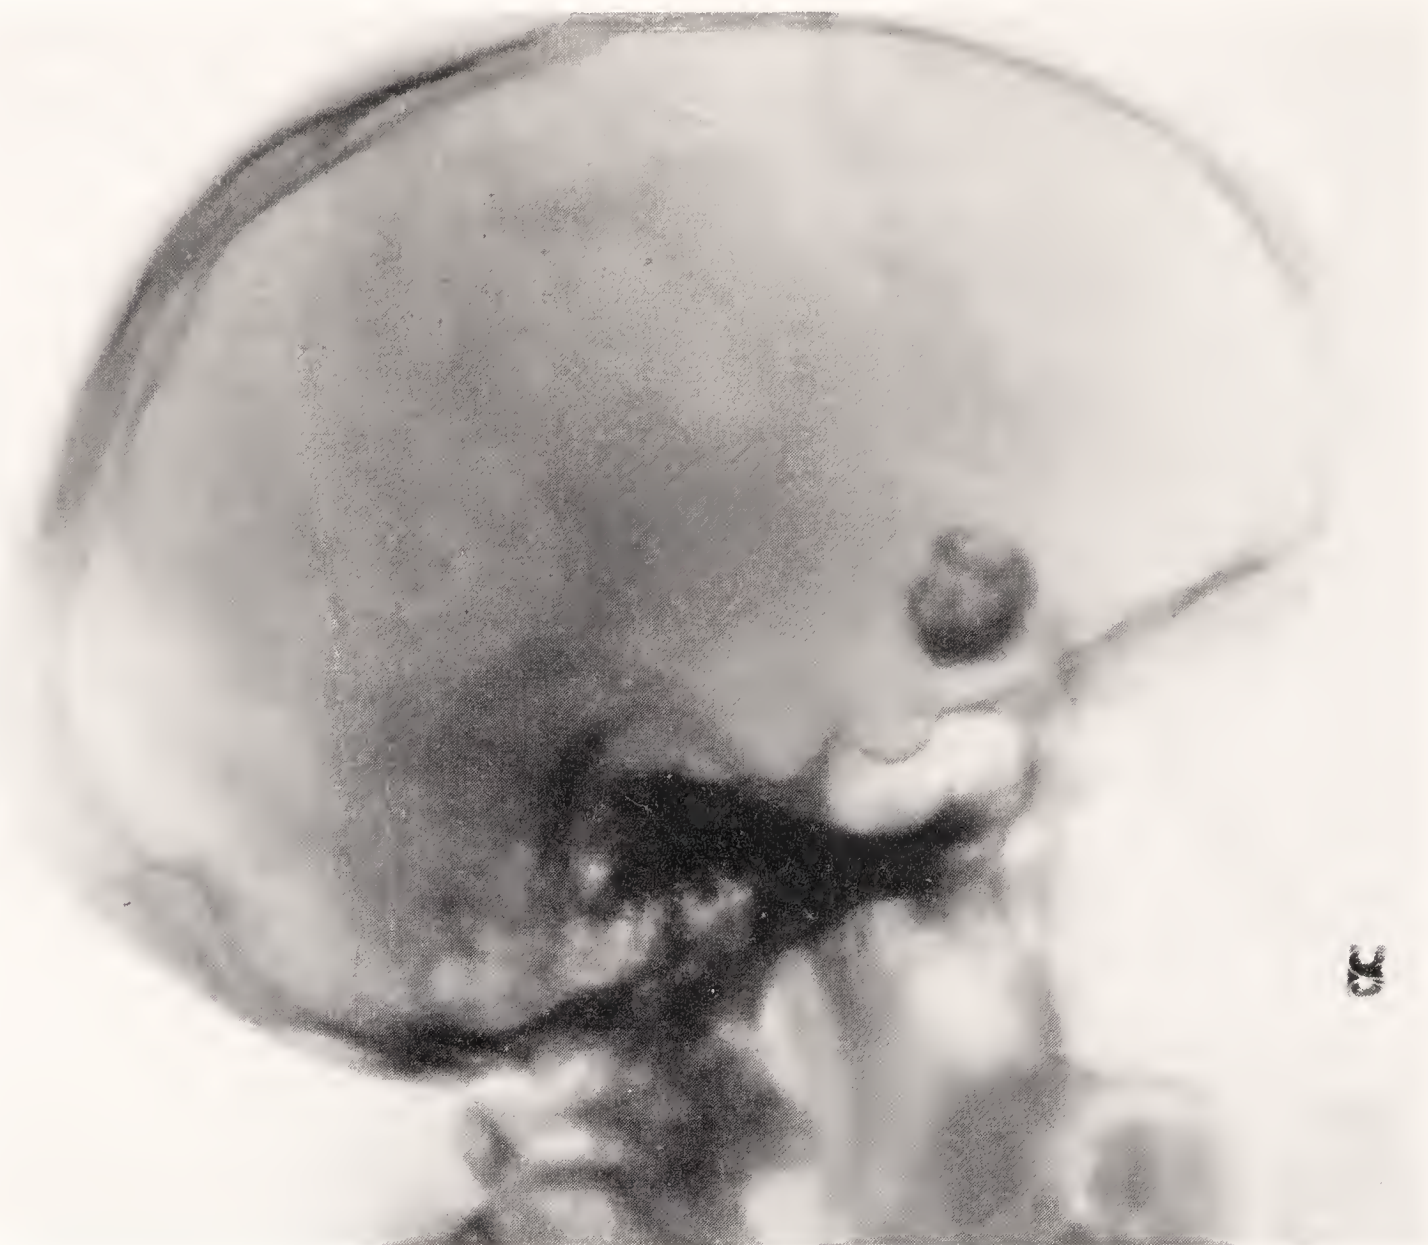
Roentgenogram disclosing solid mass of calcification deep in temporo-frontal region (*cf.* Fig. 54).
